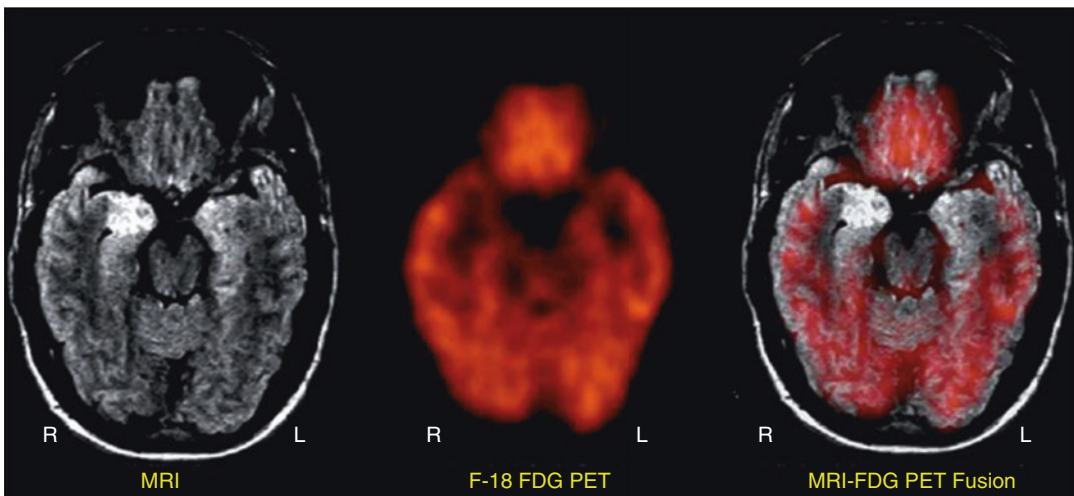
Right mesial temporal lobe sclerosis in a 16-year-old boy. (*Left*) MRI shows abnormal high signal intensity in the right mesial temporal lobe (hippocampal region). (*Middle*) FDG PET scan shows a focal reduction
